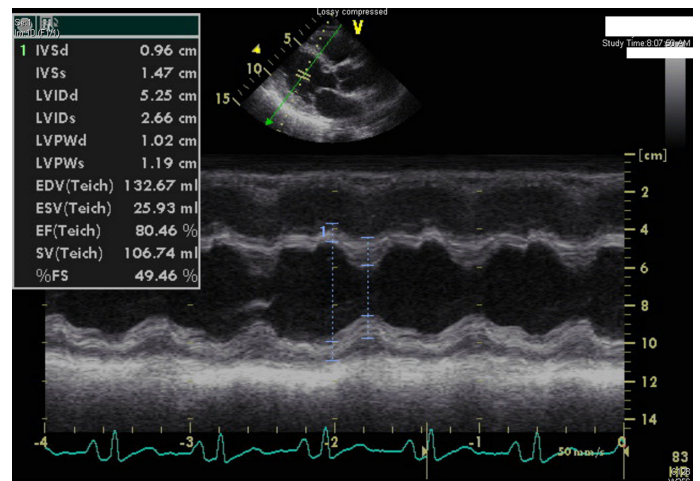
M-mode Echocardiogram through LV showing recovery of LV and normal wall motion.
